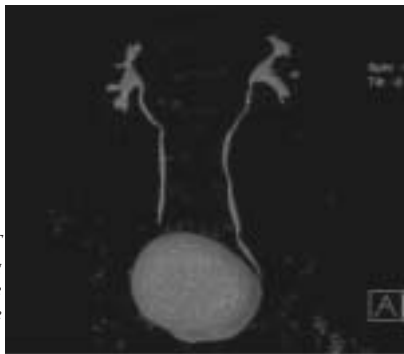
Normal CT urogram image using volume rendering with bone editing displaying the entire urinary tract.
